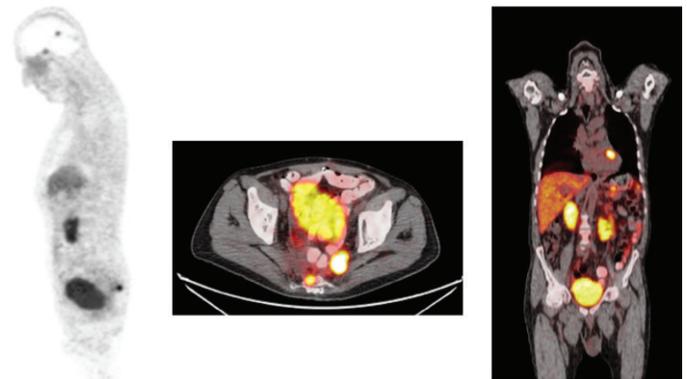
Fifty-six year-old male patient, referred for re-staging. He had rectum NET, ki-67 6% grade 2 tumor, was under sandostatatine treatment before DOTA-TATE PET/CT scan. PRRT decision was given after PET/CT images revealed relapse in pelvic region, metastatic lesions in heart and cranium
